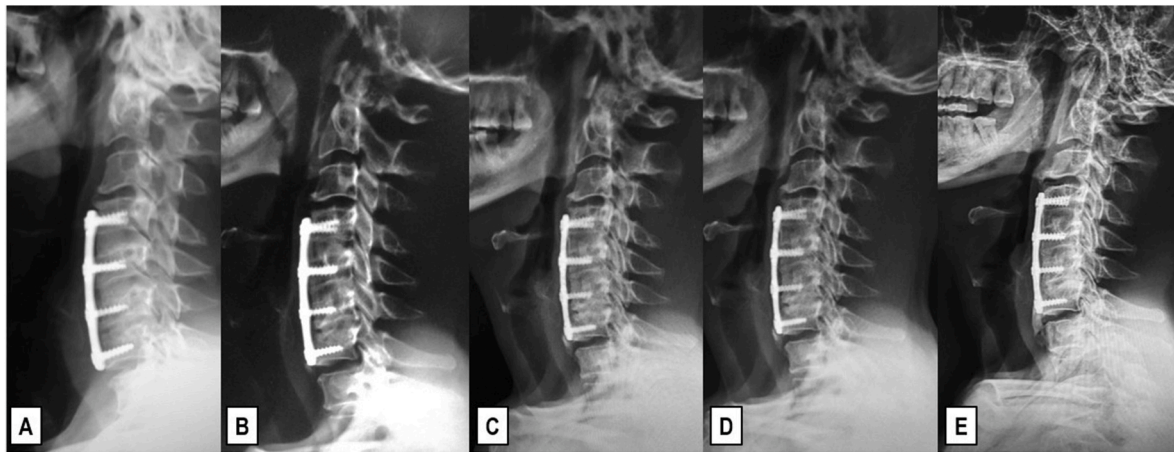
Radiographic x-ray outcome after anterior osteophyctomy combined with ACDF plus plate fixation at 3 months (A), 6 months (B), 1 year (C), 3 years (D) and 5 years (E) follow up.
